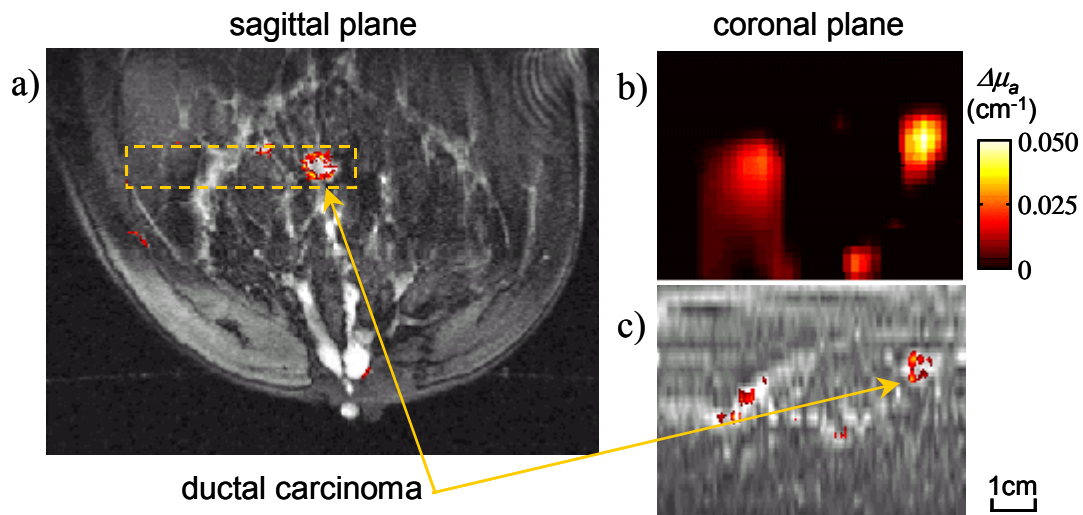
Ductal carcinoma (case I). *a)* Functional sagittal MR image after Gd contrast enhancement passing through the center of the cancerous lesion. *b)* Coronal DOT image, perpendicular to the plane of the MRI image in (a), for the *volume of interest* (VOI) indicated on (a) with the interrupted line box. *c)* Functional MR coronal re-slicing of the VOI with the same dimensions as (b).
